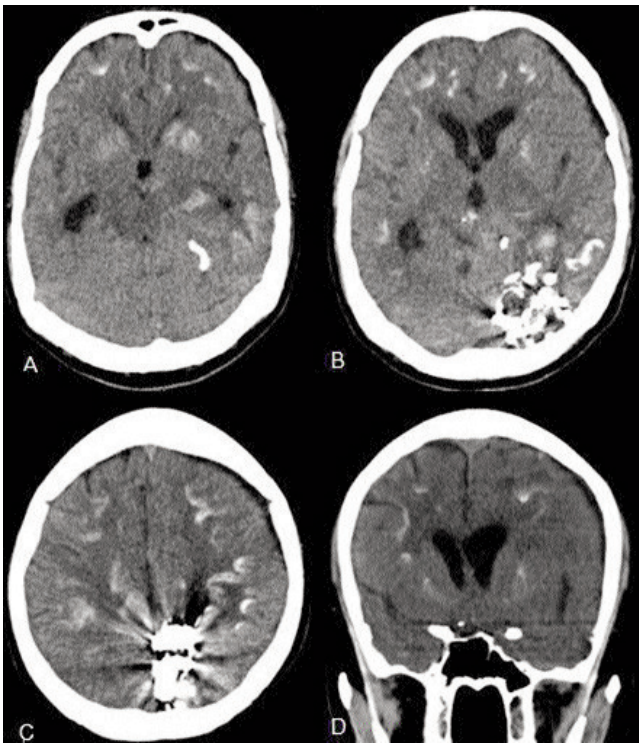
Axial and reconstructed coronal images of unenhanced CT study showing bilateral symmetrical diffuse subcortical and basal ganglia calcifications. High density in left parieto-occipital region is due to glue deposition from previous AVM embolization.
